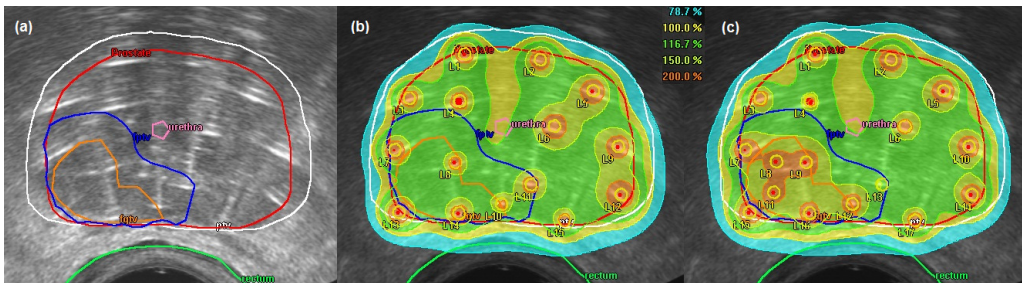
(a) MRI F-GTV registered to TRUS and used to generate F-PTV (b) isodoses from the standard plan (c) isodoses from the focal boost plan
